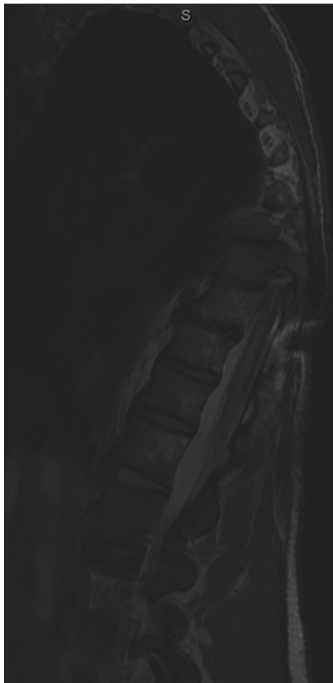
A T2-weighted sagittal magnetic resonance imaging of the thoracic spine demonstrating increased intramedullary T2 signal that extends to the conus medullaris. There is considerable artifact from instrumentation that obscures the mid- and most of the upper thoracic spine.
